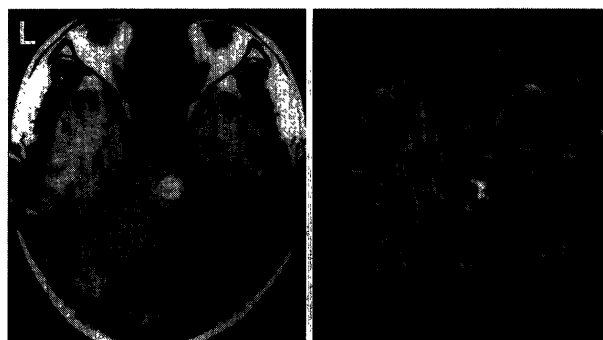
Case 2. T<sub>1</sub>- (*left*) and T<sub>2</sub>-weighted (*right*) SE MR images, showing a heterogeneous lesion at the right tegmentum. He presented with the cheiro-oral syndrome.
